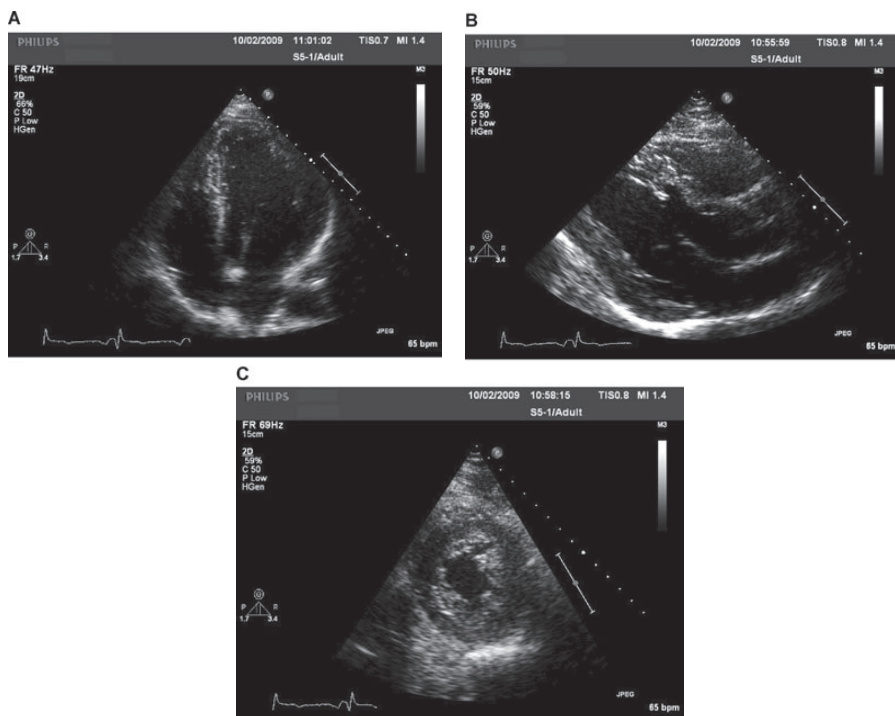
A, B, and C. The echocardiographical views after 2.5 years' follow-up.
